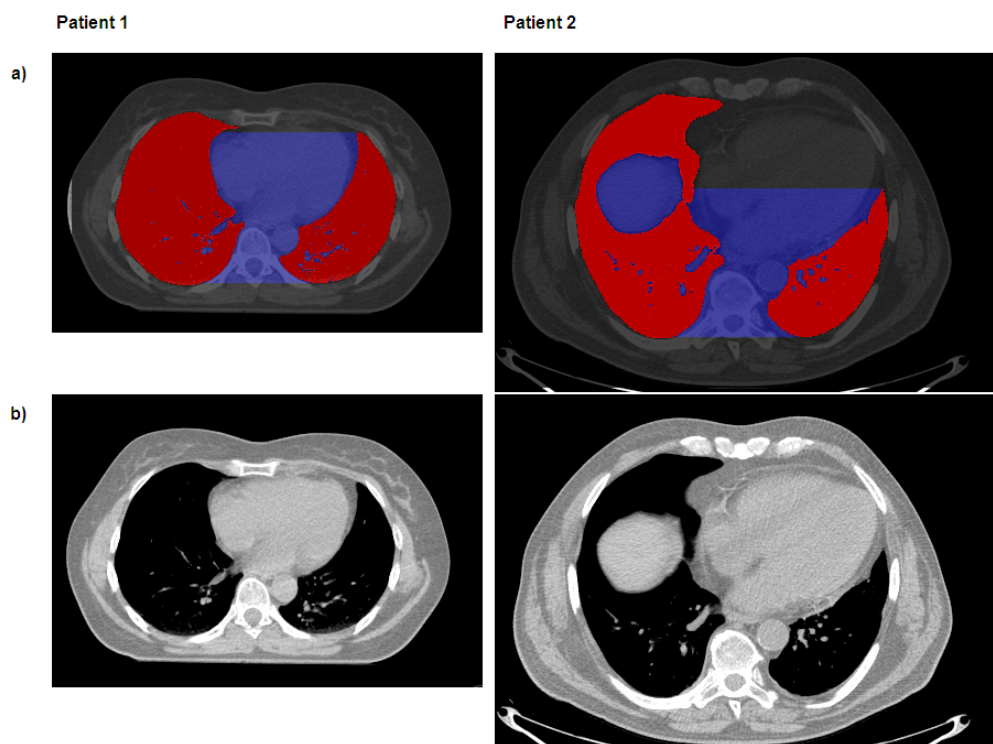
For patients 1 and 2: a) the regions obtained from the lung binary map (red) and the additional areas included by filling between the left and right lungs (blue) and b) the original CT slice. (Patients 1 and 2 correspond with patients B1 and B2 as used in Chapter 5 on page 129.)
